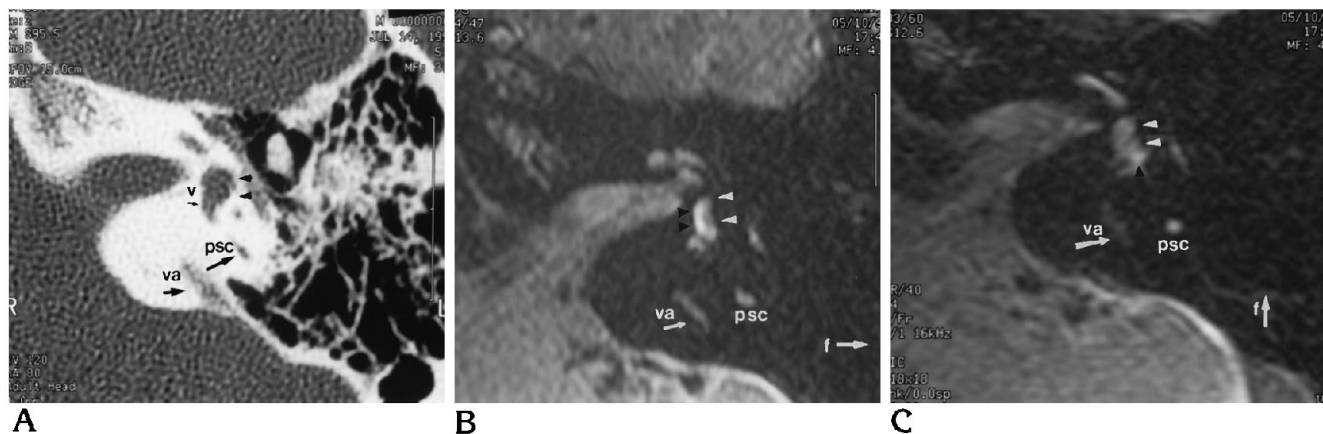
CT and MR comparison.
